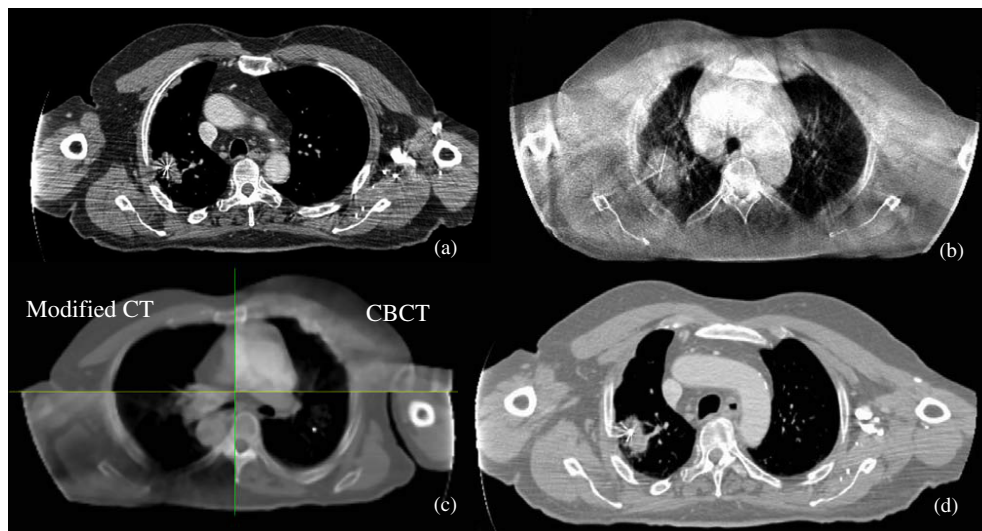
CT, CBCT and modified CT images for the lung case: (a) planning CT; (b) CBCT; (c) checkerboard image after the deformation registration; and (d) modified CBCT.
